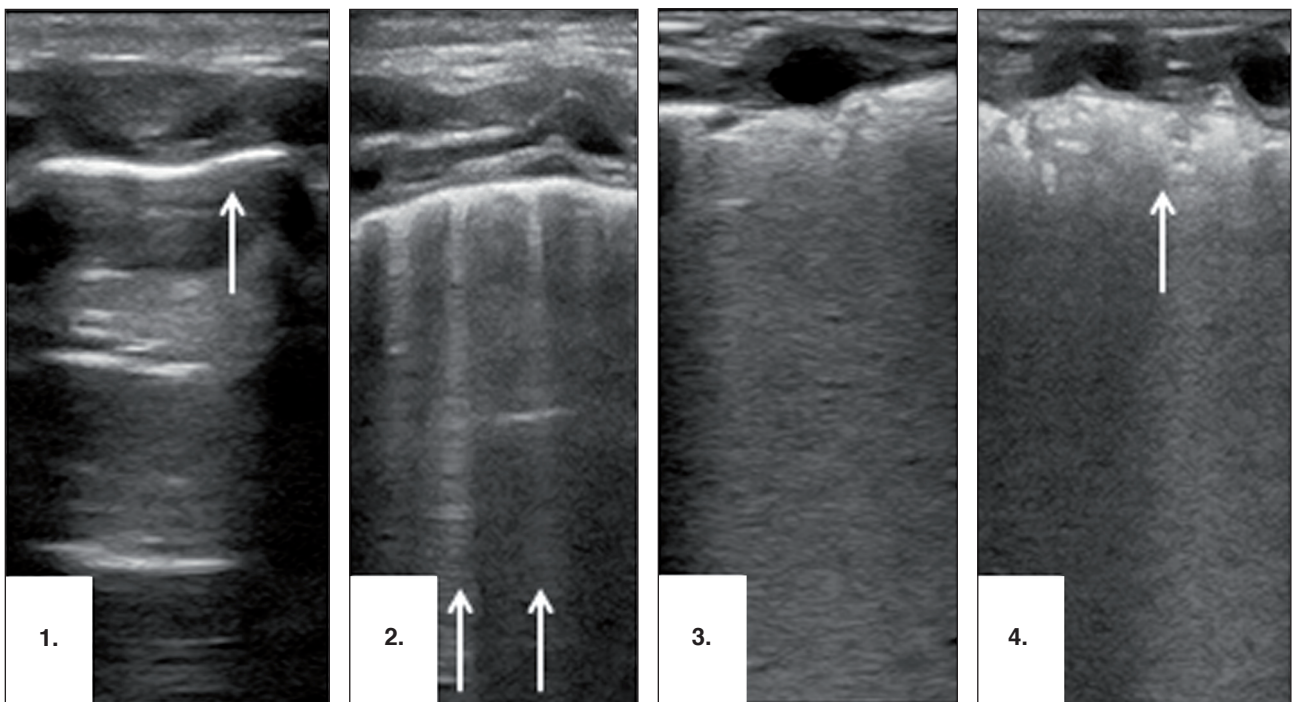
Four typical patterns of lung ultrasound. 1. Normal lung aeration with transverse repetition of pleural image which is artifact A-line (arrow), absent sliding in this pattern signifies pneumothorax. 2. Longitudinal separated B-lines (arrows) reaching the bottom of the image signifies interstitial fluid (transient tachypnea of the newborn [TTN] pattern). 3. Coalescent B-lines with homogenous echographic view and thickened pleura (respiratory distress syndrome [RDS] pattern). 4. Same as 3 with subpleural air bronchogram (arrow) bronchopulmonary dysplasia [BPD] pattern.
